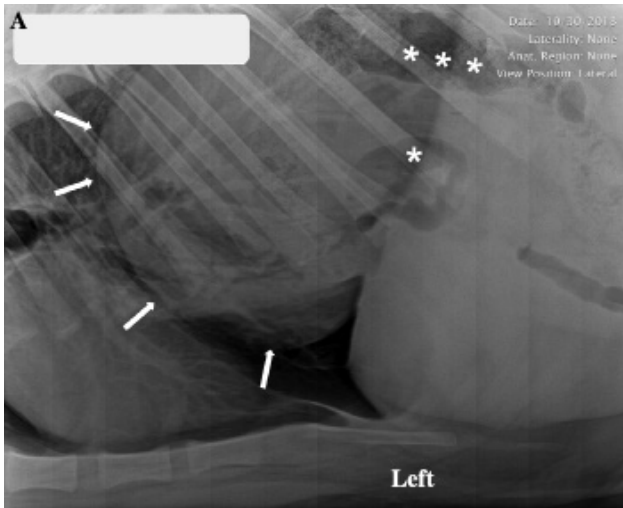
Same radiographic image as in Figure 1. There is a large, well-defined, smoothly margined soft tissue structure (arrows) in the central to left caudodorsal aspect of the thorax. This soft tissue opaque mass has a gas-filled tubular structure (single asterisk) and a tubular structure containing heterogeneous gas and soft tissue opaque material (triple asterisks), suggestive of feces in the colon. The mediastinum (dotted lines) and cardiac silhouette are shifted rightward, exacerbated by the obliquity of patient positioning, which also causes the soft tissue mass to be superimposed with structures in the right hemithorax. There is border effacement of the caudal aspect of the cardiac silhouette by the cranial aspect of the soft tissue mass.
